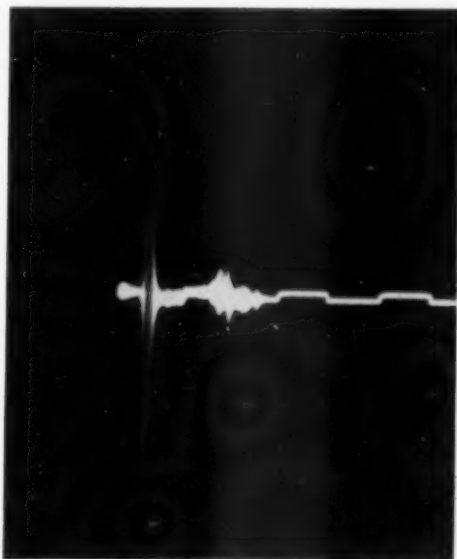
(Mundt and Hughes). Ultrasonic tracing according to the technique outlined in Figure 21 of a child's eye containing a retinoblastoma.
